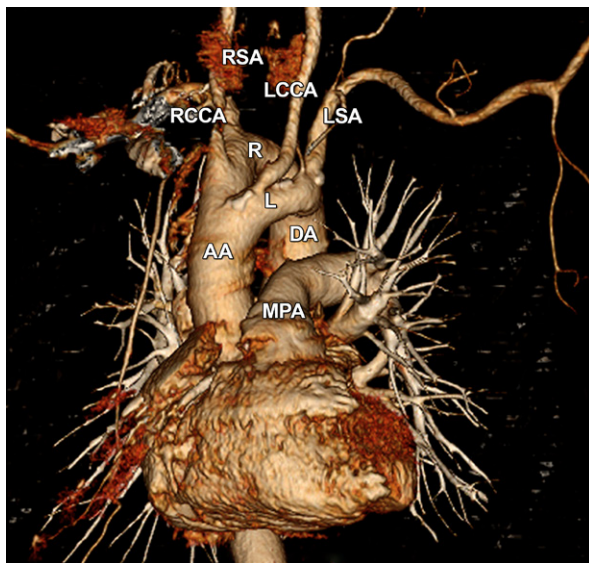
This 64-slice cardiac computed tomogram is a 3-dimensional volume rendering (left anterior oblique view) that correlates with the aortographic view in Fig. 2.
